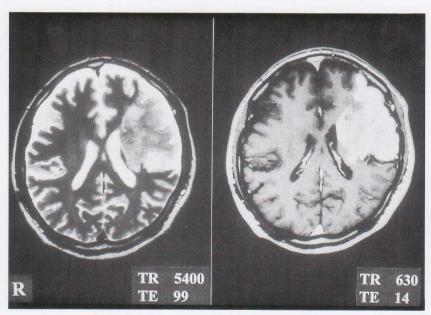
Case presentation of Case 1 (77 yrs male). (A) Comparison of ^{99m}Tc-HMPAO brain SPECT image (^{99m}Tc-HMPAO) with PET images. ^{99m}Tc-HMPAO brain SPECT image shows the increased accumulation in the left frontal cortical area, while CBF and CBV are increased but CMRO₂ and OEF are reduced. (B) T2-weighted MR image (left) (repetition time, 5400 msec; echo time, 99 msec) shows an irregular high intensity area in the left middle cerebral artery territory and T1-weighted MR image (right) (repetition time, 630 msec; echo time, 14 msec) with Gd-DTPA shows marked enhancement in that area.
